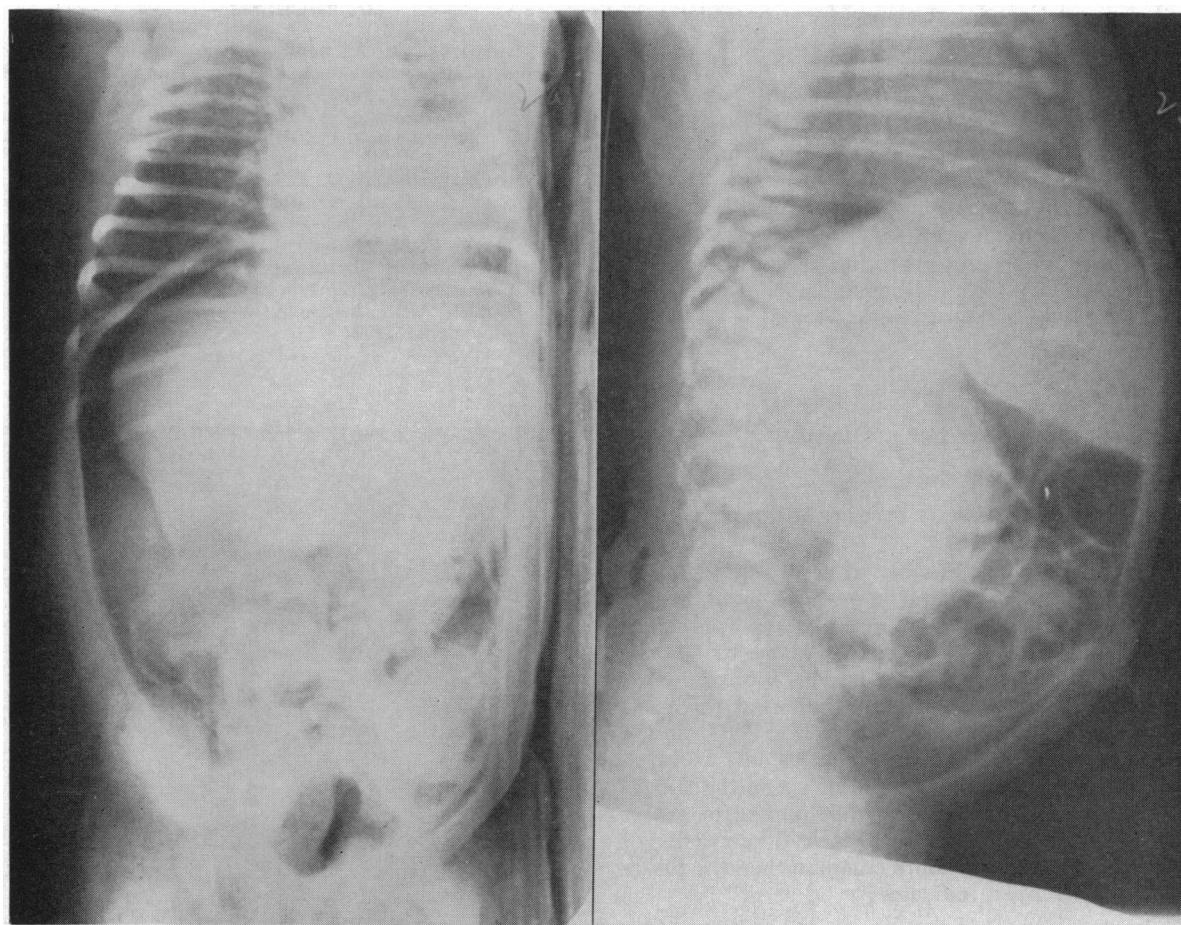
(Case 3).—Anteroposterior and lateral radiographs of the abdomen with pneumo and retroperitoneal insufflation of carbon dioxide show the right kidney encapsulated within the hematoma. The left kidney can be seen in normal position.
